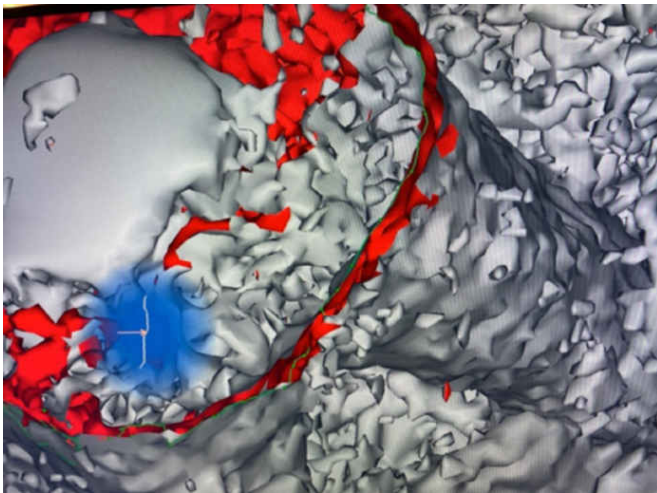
It can be seen a detailed view of the X-ray data after conversion to STL format. In the CAD programme, this should be placed as evenly as possible on a smooth tooth surface. The prepared area is defined on it, after which the CAD programme defines the edge of the tooth crown. Due to the selected Hounsfield unit area, many artefacts occur. Defining the preparation margin (green line) is made difficult by the coral-like irregularities. The red area marks all surface areas that lie at the preparation margin.
